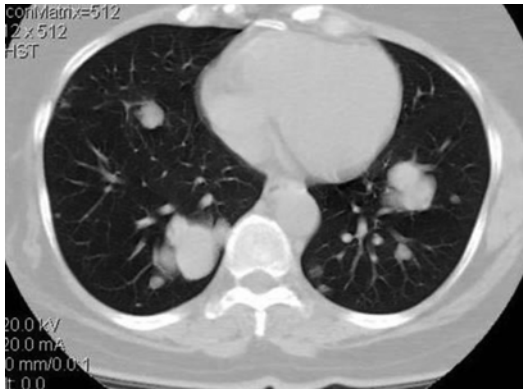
Contrast-enhanced axial CT scan showing multiple lobulated masses in both lung fields suggestive of lung metastasis
